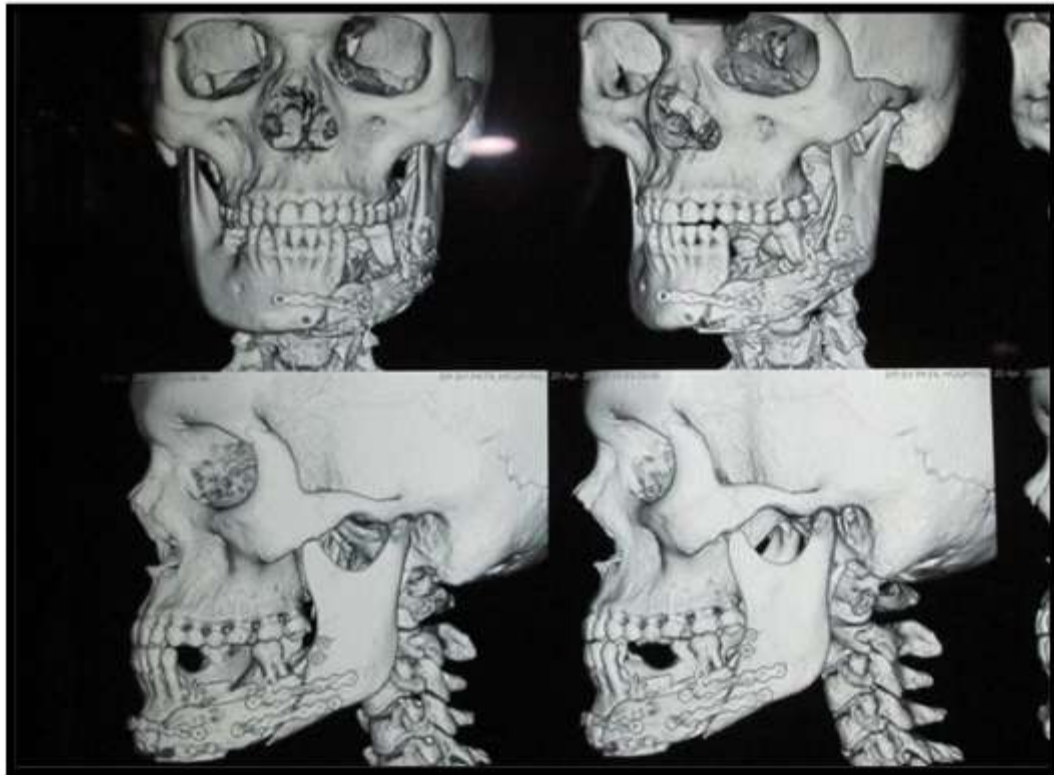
3D reconstruction computed tomography showing the titanium plates and screws in various facial angle.
